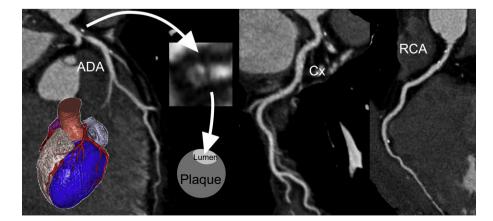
Cardiac CT assessment of the coronary anatomy in a patient with chest pain. There is a large plaque in the distal trunk, which extends to the anterior descending artery and causes severe ostial stenosis. The low-attenuation, obstructive plaque causes vessel remodelling. It therefore fulfils all the high-risk criteria. ADA, anterior descending artery; CT, computed tomography; Cx, circumflex artery; RCA, right coronary artery.
